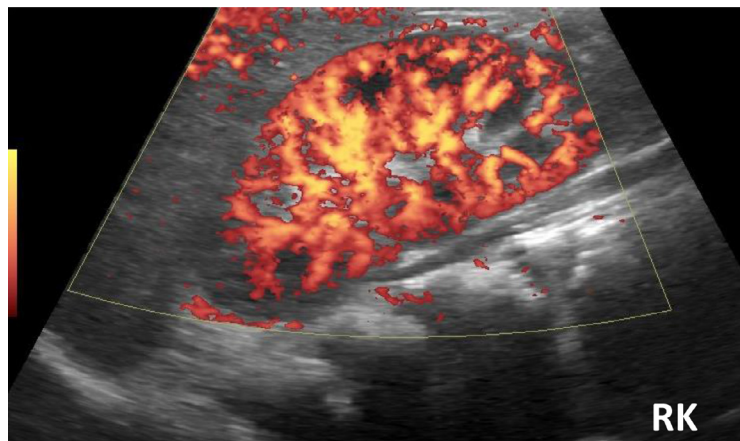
Follow-up color-Doppler US (CD-US) post-angioplasty: a great vascularization in the right kidney, overall the parenchyma to the outer portion of the subcortex.
